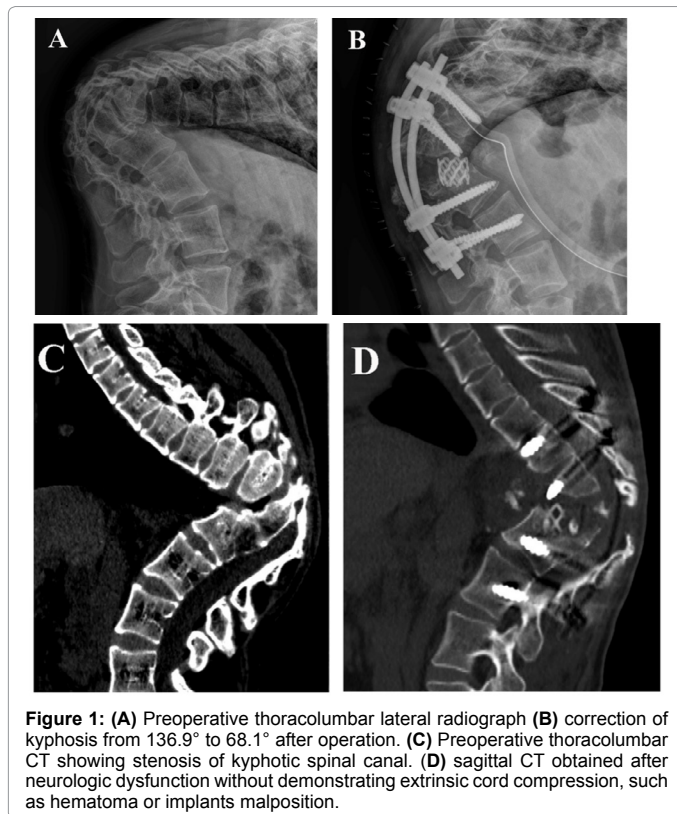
(A) Preoperative thoracolumbar lateral radiograph (B) correction of kyphosis from 136.9° to 68.1° after operation. (C) Preoperative thoracolumbar CT showing stenosis of kyphotic spinal canal. (D) sagittal CT obtained after neurologic dysfunction without demonstrating extrinsic cord compression, such as hematoma or implants malposition.
